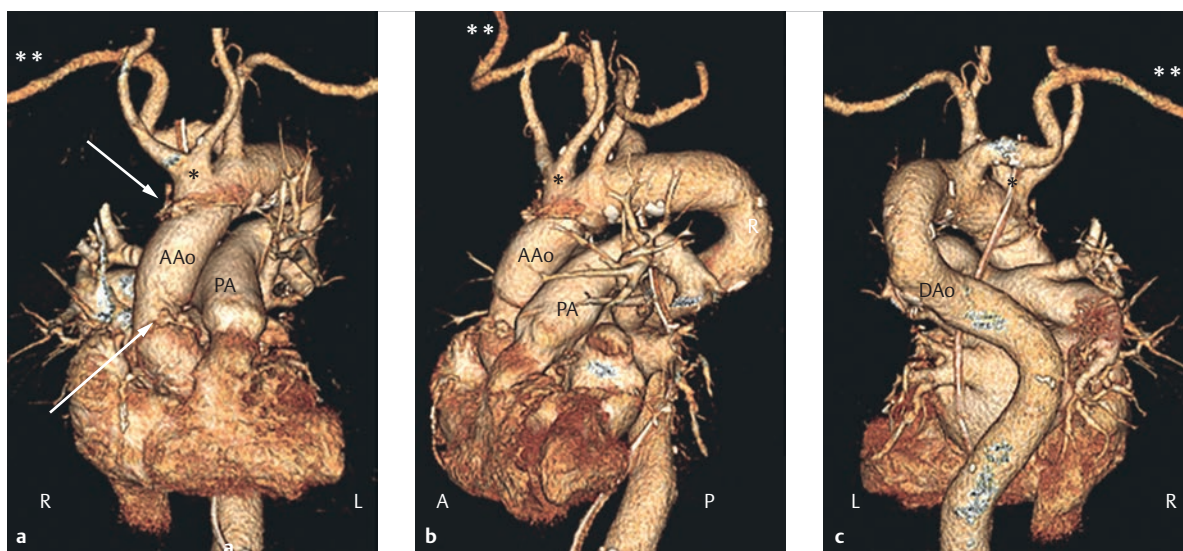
Lusorian artery and truncus bicaroticus subclavius after replacing the ascending aorta. Seventy-seven-year-old male patient who received an aortic valve reconstruction, ascending aorta replacement, and partial arch replacement (a, arrows) due to acute type A dissection. The postoperative CT check-up reveals a truncus bicaroticus (a–c, asterisks) as an anatomical variant of the supraaortic vessels, in conjunction with a lusorian artery (a–c, double asterisk).
